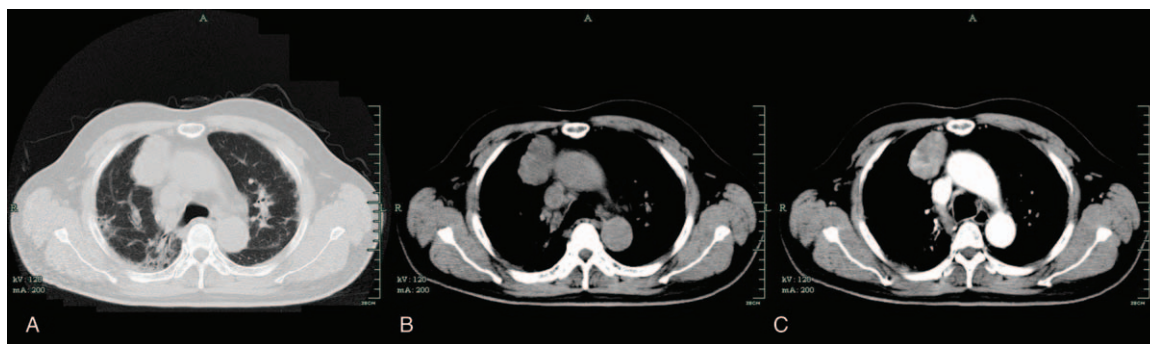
(A) Lung window. Lung CT shows 2 lungs with patchy grid hyperdensity remarkable under the pleura. A mass is located in the anterior mediastinum. (B and C) Mediastinum window. The anterior mediastinal mass shows a heterogeneous texture, a clear boundary, and inhomogeneous enhancement. CT= computed tomography.
